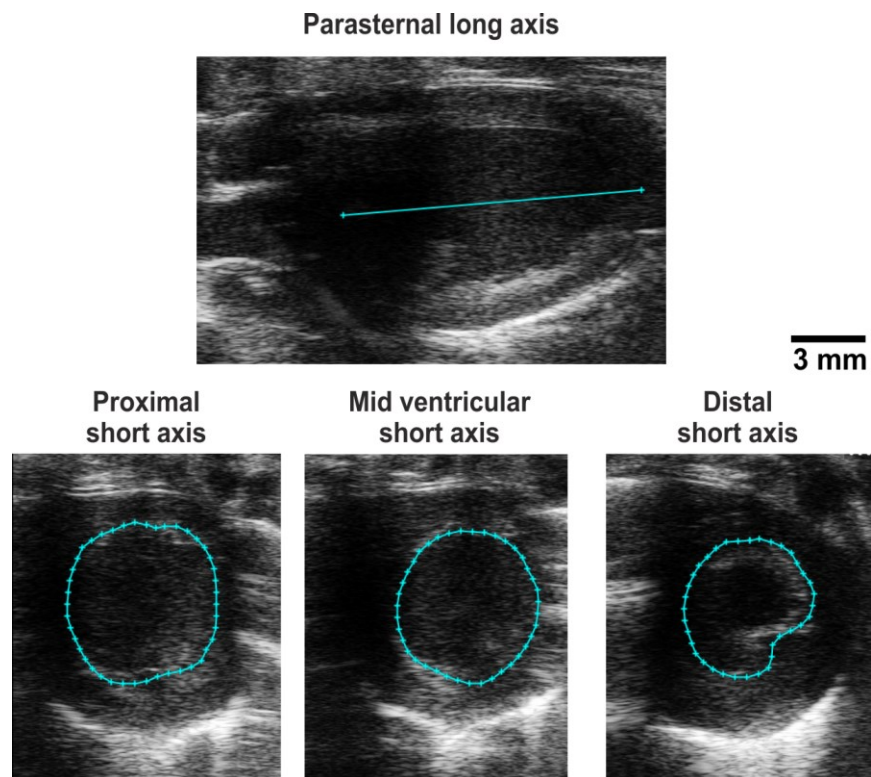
Ultrasound imaging of the left ventricle
